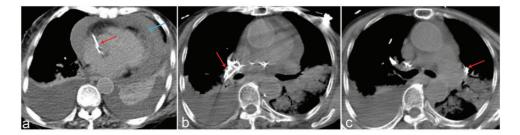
Images of intracardiac and pulmonary cement embolism. (a) Computed tomography showed high-density foreign bodies in the right atrium (red arrow) resulting in pericardial tamponade (blue arrow) and (b, c) Cement embolisms were present in the left pulmonary artery and right lower lobe pulmonary artery (red arrow).
